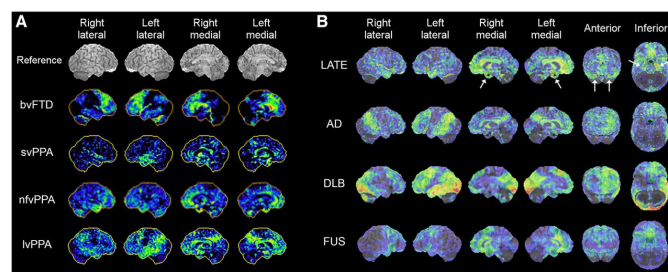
Example z-scores of FDG-PET images from patients with different neurodegenerative diseases relative to healthy controls; A. top to bottom: frontotemporal dementia behavioral variant (bvFTD), semantic variant primary progressive aphasia (svPPA), nonfluent variant primary progressive aphasia (nfvPPA), logopenic variant primary progressive aphasia (lvPPA); B. Images on this side are superimposed on the reference MRI image. top to bottom: limbic-predominant age-related TDP-43 encephalopathy (LATE), Alzheimer's disease (AD), dementia with Lewy bodies (DLB), fused in sarcoma (FUS). Image source from (Minoshima et al. 2022), used in accordance with the Journal of Nuclear Medicine's policy regarding non-commercial reuse of excerpted material:
